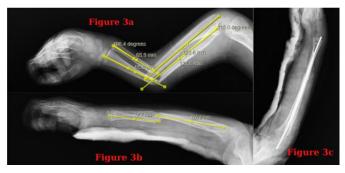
Pre-reduction (Figure 3a) and Post-reduction (Figure 3b) Lateral Radiographs of 8 years old boy with both radius and ulna diaphyseal forearm fractures were treated surgically(titanium elastic nail)(3c) by Orthopedic Surgeon.
